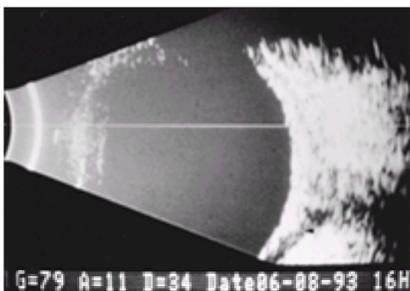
Orbital ultrasound of a patient with globe tenderness, erythema, and conjunctival swelling. Fluid collection is present outside the sclera (arrowhead). Posterior scleritis was responsive to oral corticosteroids.
